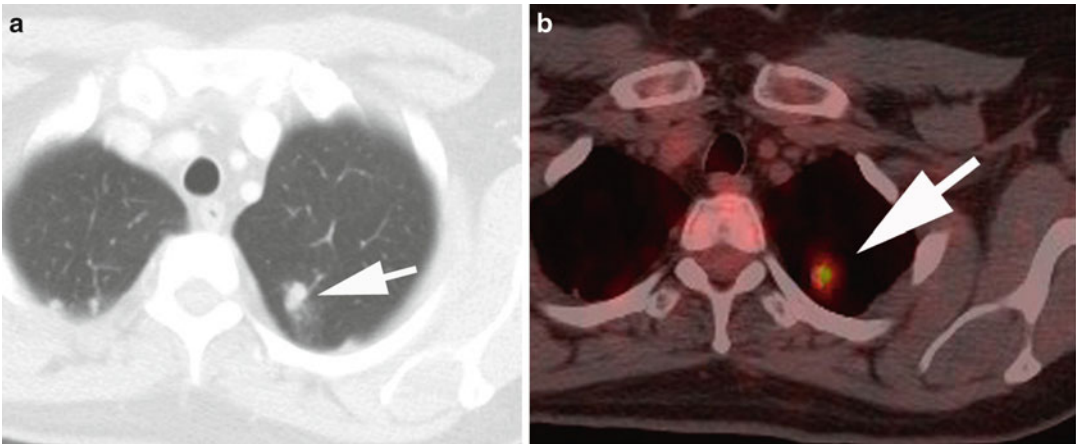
False-positive PET/CT. (a) Axial CT image reveals spiculated left upper lobe nodule suspicious for malignancy. (b) Fused PET/CT image shows elevated
